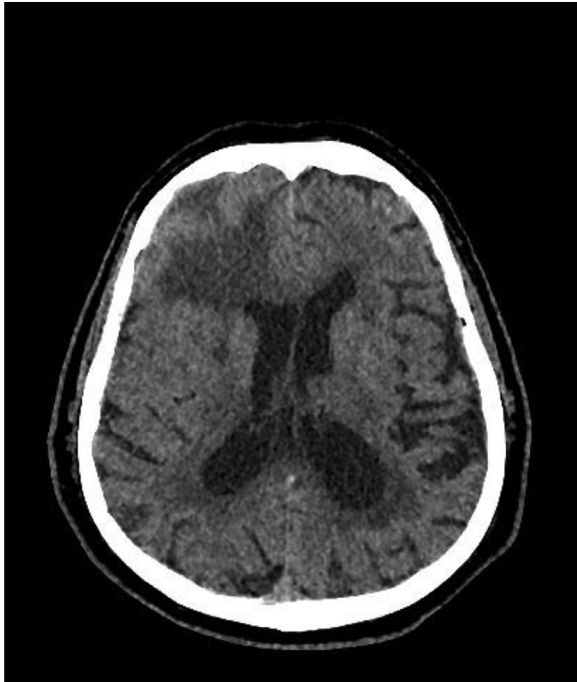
Noncontrast axial CT image. Inhomogeneous parenchymal lesion localized to the right frontal lobe with perifocal edematous component.
